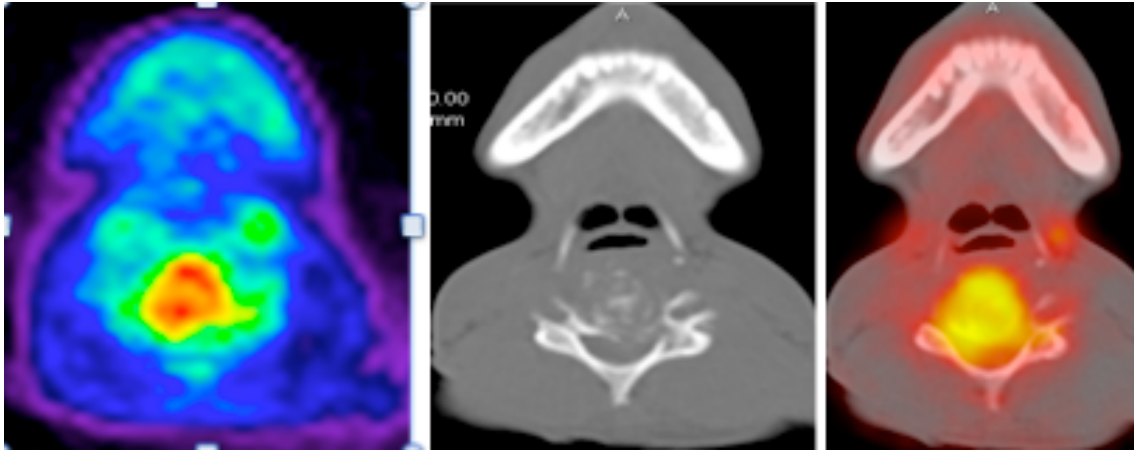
A 44 yr old male with HIV and TB (Absolute CD4 196 x106/l) who presented with quadriparesis. CT demonstrates destruction of the vertebral bodies of C4/C5 and the intervertebral disc with intense tracer accumulation in this region. Dual-time point imaging was performed following IV injection of 257.5 MBq (6.96mCi) of ⁶⁸Ga-citrate and IV contrast. SUVmax₁ of 3.83 decreased by 2% to a SUVmax₂ of 3.75. (Liver SUVmax: 3.24).
